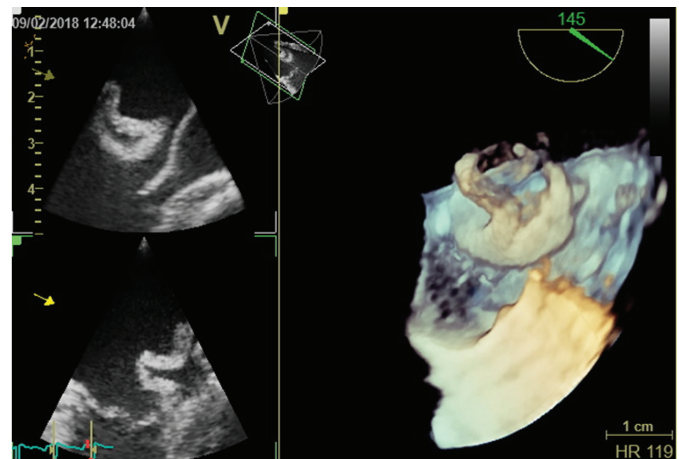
Three-dimensional transesophageal echocardiography: mitral valve pseudoaneurysm.
